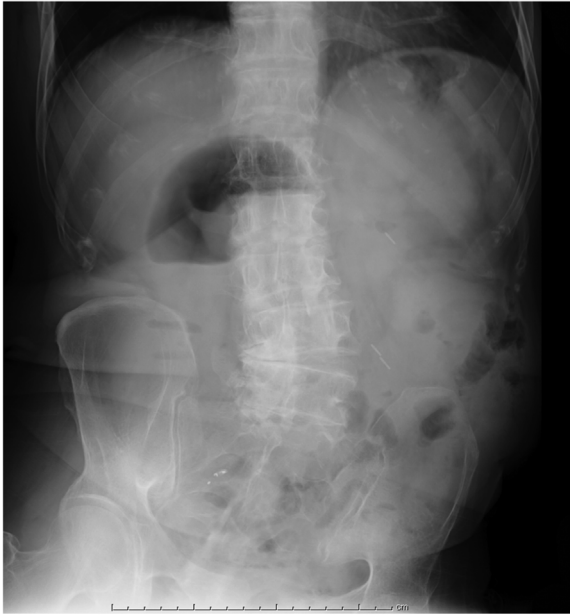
A plain abdominal radiograph obtained on re-admission, showing a small amount of intestinal gas in the upper abdomen.
